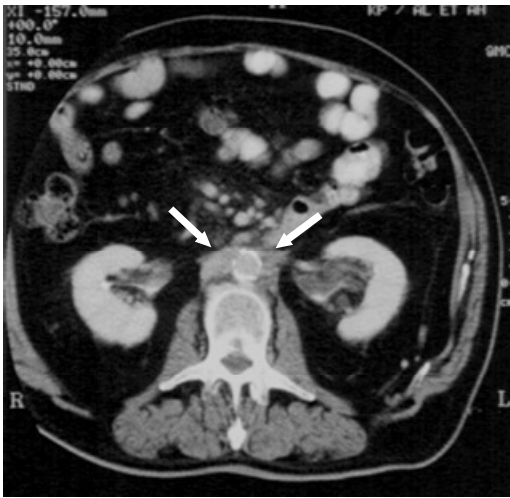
Abdominal CT scan of a former insulator in power plants. There is a thick mass covering the abdominal aorta (white arrows). This follow-up scan was made 15 years after the initial diagnosis of RPF.
